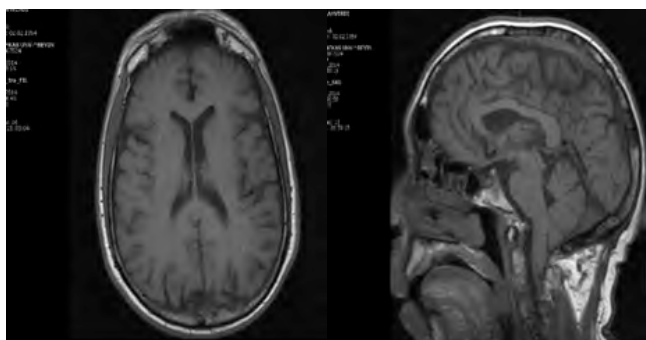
T1- Weighted axial and sagittal cranial MRI showed mild generalized cortical atrophy
